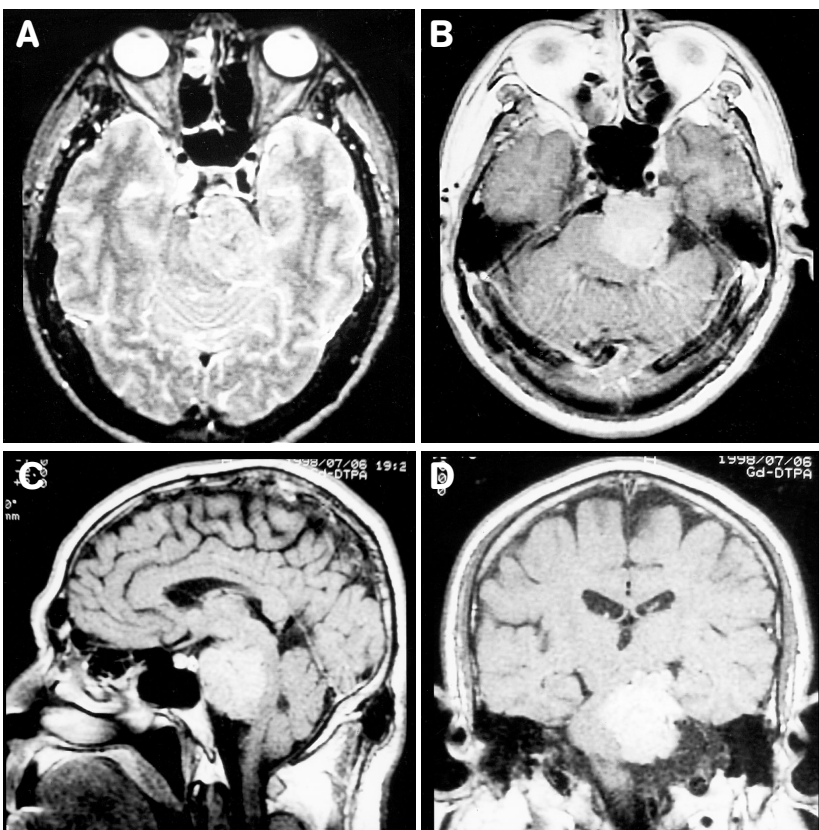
Axial T2-weighted SE (A) and axial (B), sagittal (C), coronal (D), and post-gadolinium T1-weighted SE showed a homogenous iso-intense and high-enhanced well-circumscribed mass lesion with extension of left Meckel's cave in widened left preponine cistern.
